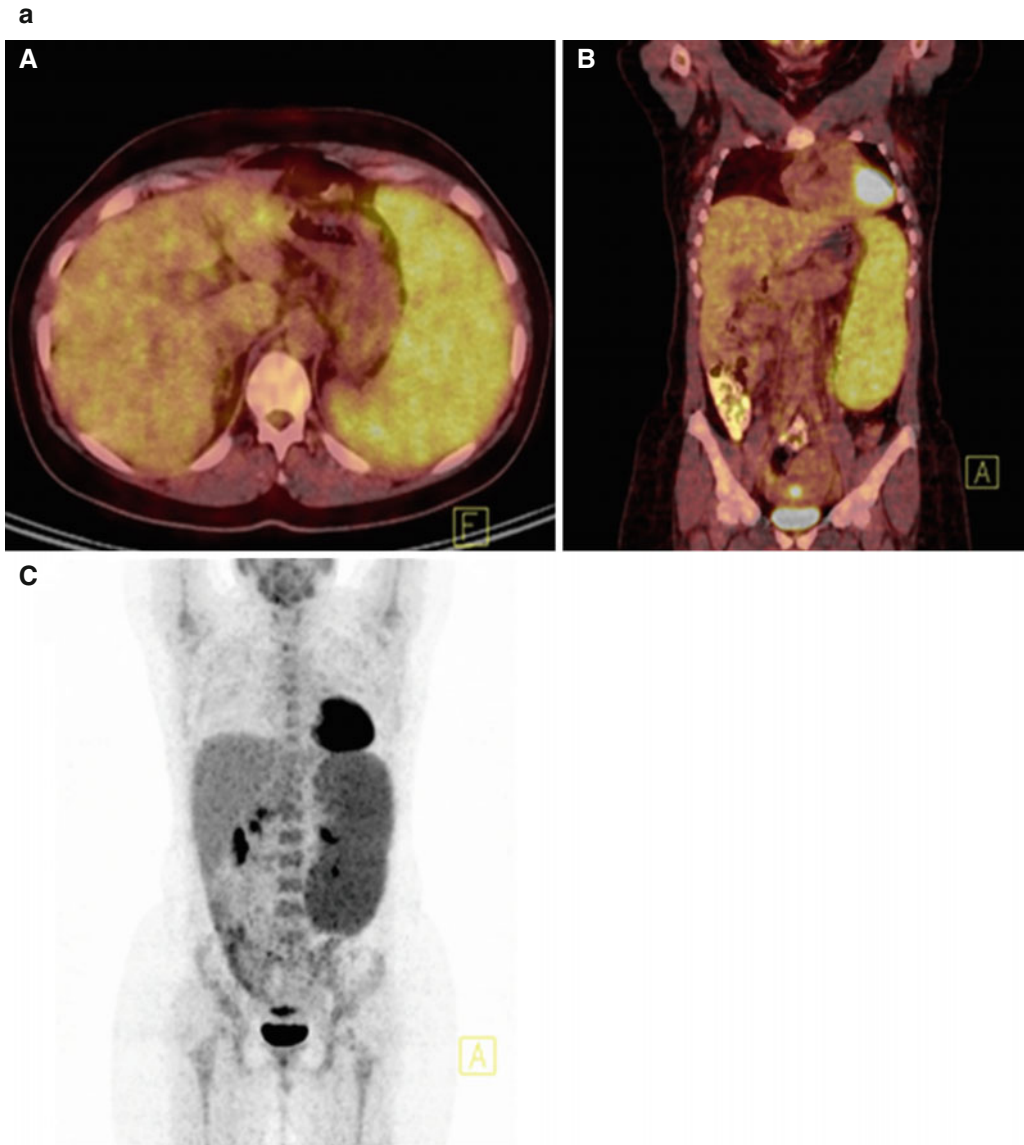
(a) Axial and coronal PET/CT images (A, B) and PET MIP image (C) show the enlarged spleen with diffusely increased uptake of the radiopharmaceutical (SUVmax 5,8). (b) In axial and coronal PET/CT images
